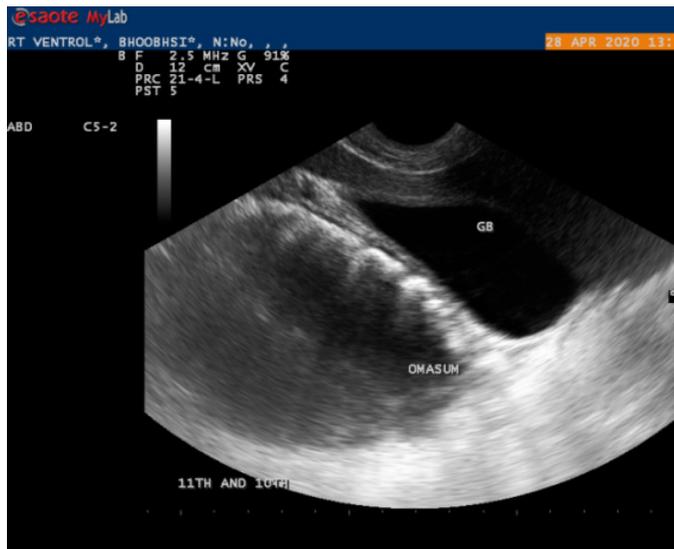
Sonogram of liver showing gallbladder as a pear-shaped anechoic structure with a hyperechoic wall and echogenic wall of the omasum at the ventral border of the liver.
